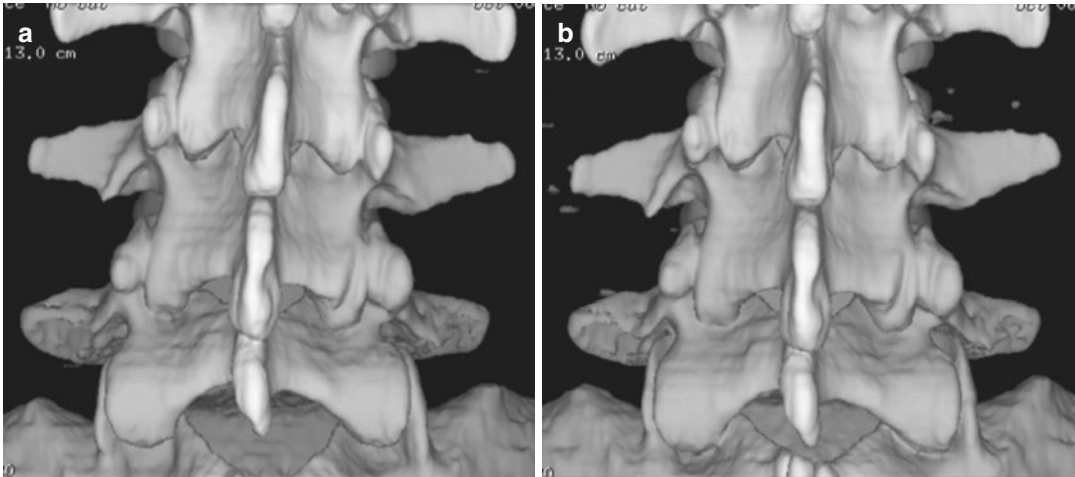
Occult facet joint instability demonstrated on axial-loaded CT scan (courtesy of R. Cartolari). On 3D preload image, normal aspect of L5/S1 facet joint (a).
